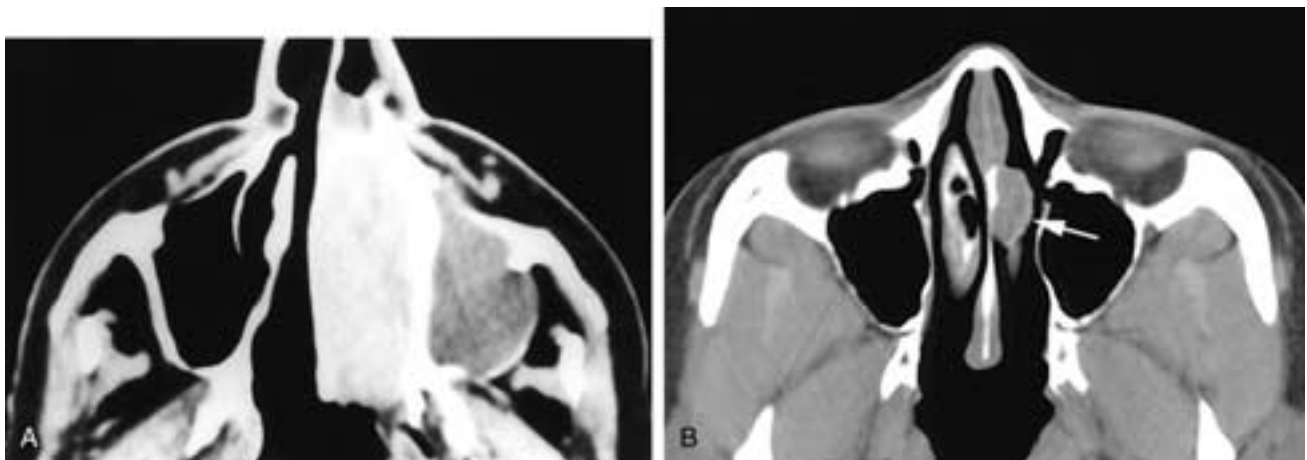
Axial CT scan (A) shows a large, expansile, enhancing mass in the left nasal fossa that has obstructed the left maxillary sinus, causing a mucocoele to form, as noted by the modeled left antral wall. The nasal vault bones are intact. This patient had an inverted papilloma. Axial CT scan (B) on another patient shows a polypoid mass arising from the left side of the nasal septum (arrow). No erosion of the septum is seen. This patient had a fungiform papilloma.
